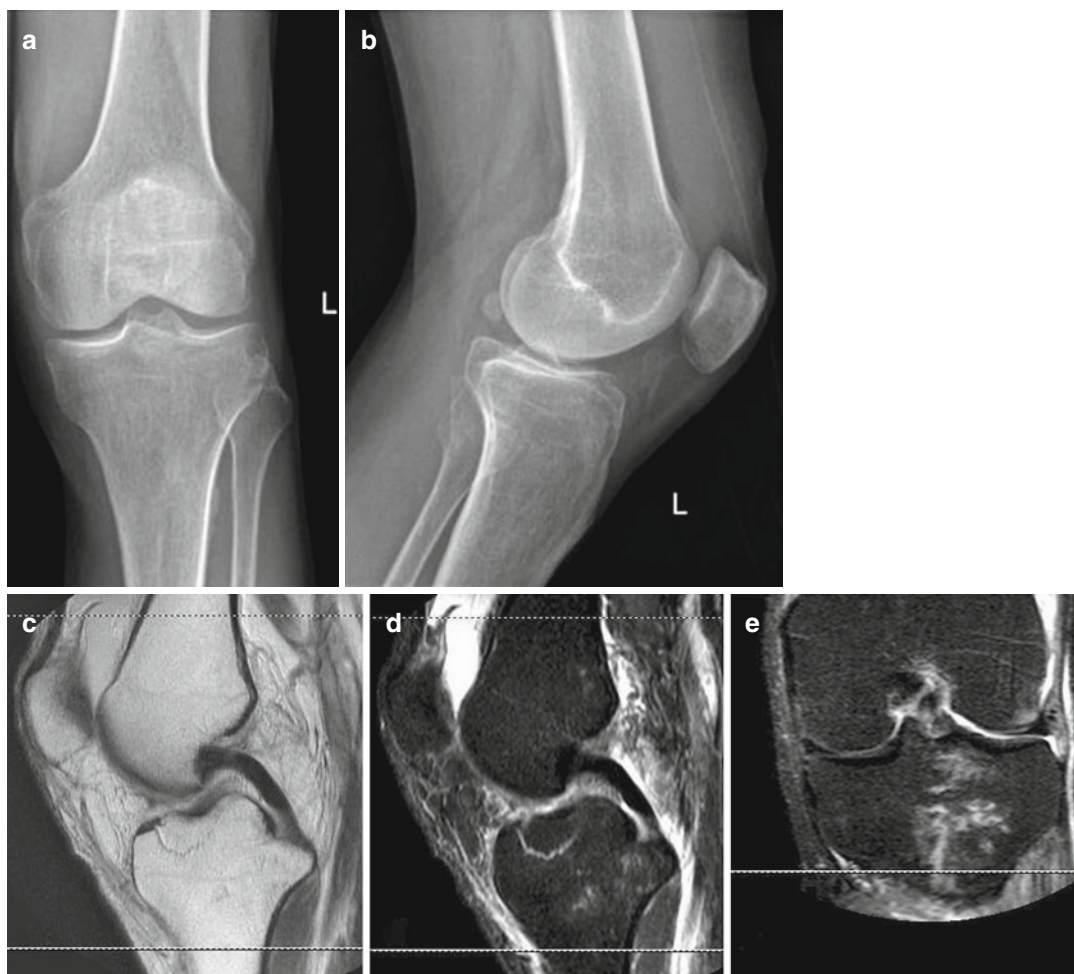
Left knee study after trauma. Plain radiographs (a, b) do not show signs of traumatic lesions. MRI, performed after aspiration of hematic joint fluid, shows composed fracture of tibia plateau (c–e)
